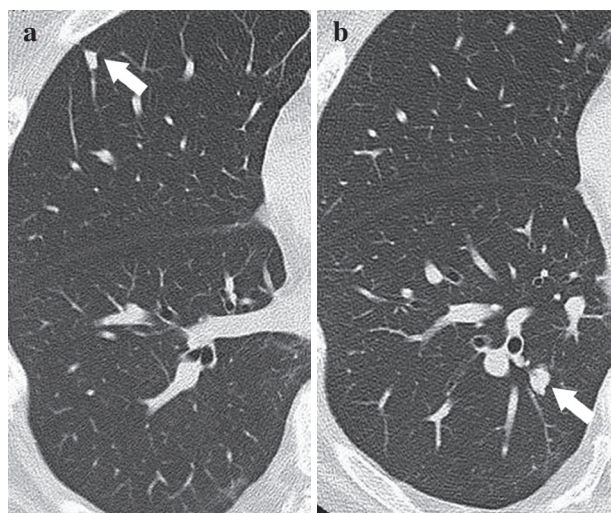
(a) A chest CT image obtained two years after initial evaluation. Arrow indicates a small nodule found in the S4 segment of the right lung. (b) The different slice of the same CT study as Figure 1 (a) that includes the S10 nodule. Arrow indicates the S10 nodule found in the right lung.
